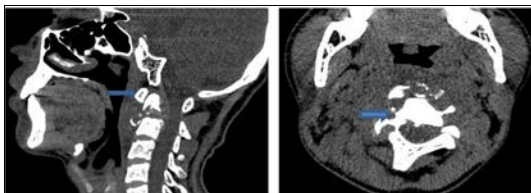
MRI Cervical Spine sagittal plane showing fracture of os odontoideum with displacement of odontoid process anteriorly (grade 2). Also, retroflexion of C2 vertebral body noted causing spinal canal stenosis, effacement of anterior subarachnoid space and compression of spinal cord
